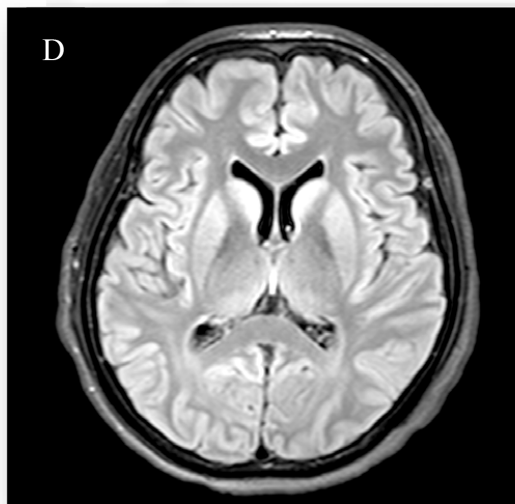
Axial MRI brain (inner back cover)
